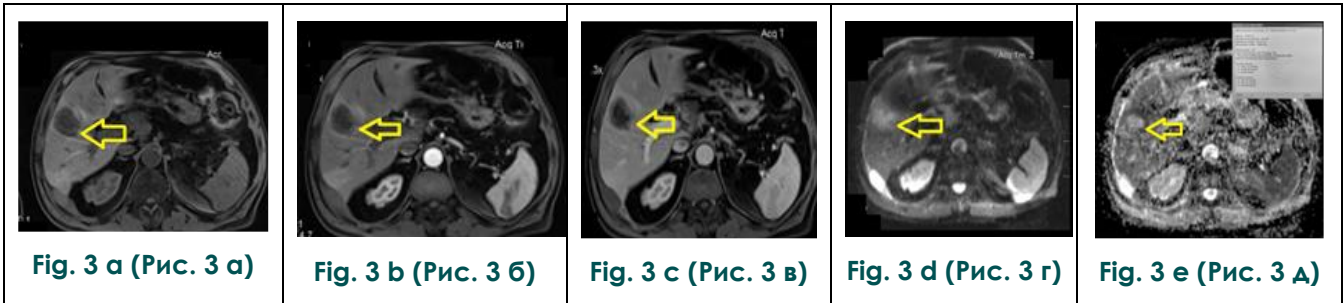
MRI of 58- years-old man with metastatic prostate cancer in liver.
